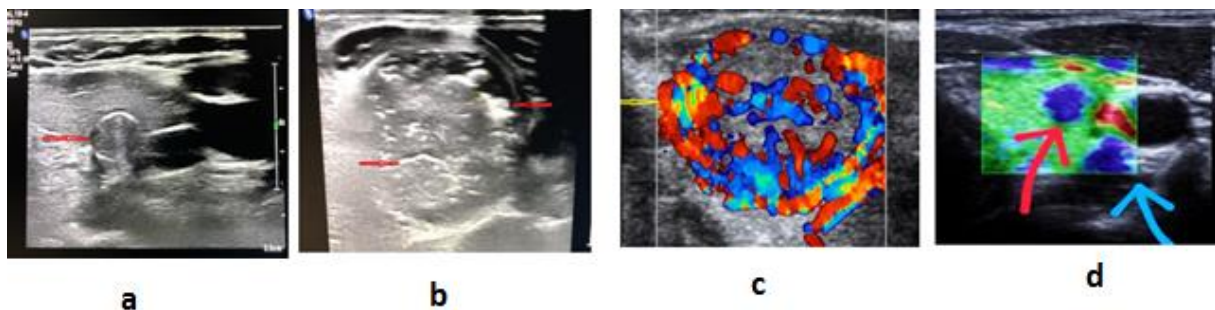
Intermittent calcifications in the thyroid nodule wall. a: coarse intranodal calcifications; b: intensely bloody nodule; c: and hard nodules on elastsonography; d: in TIRADS 4 categories.
